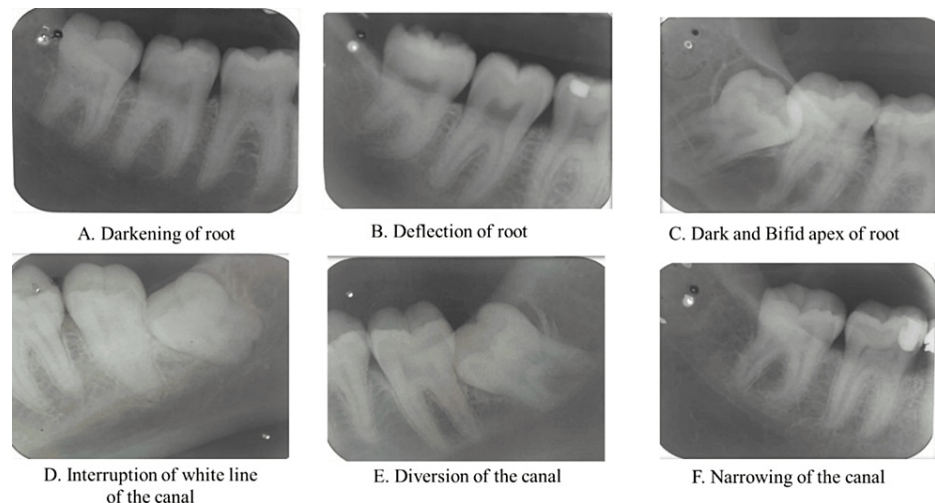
Intraoral periapical radiographs showing radiographic signs of proximity
